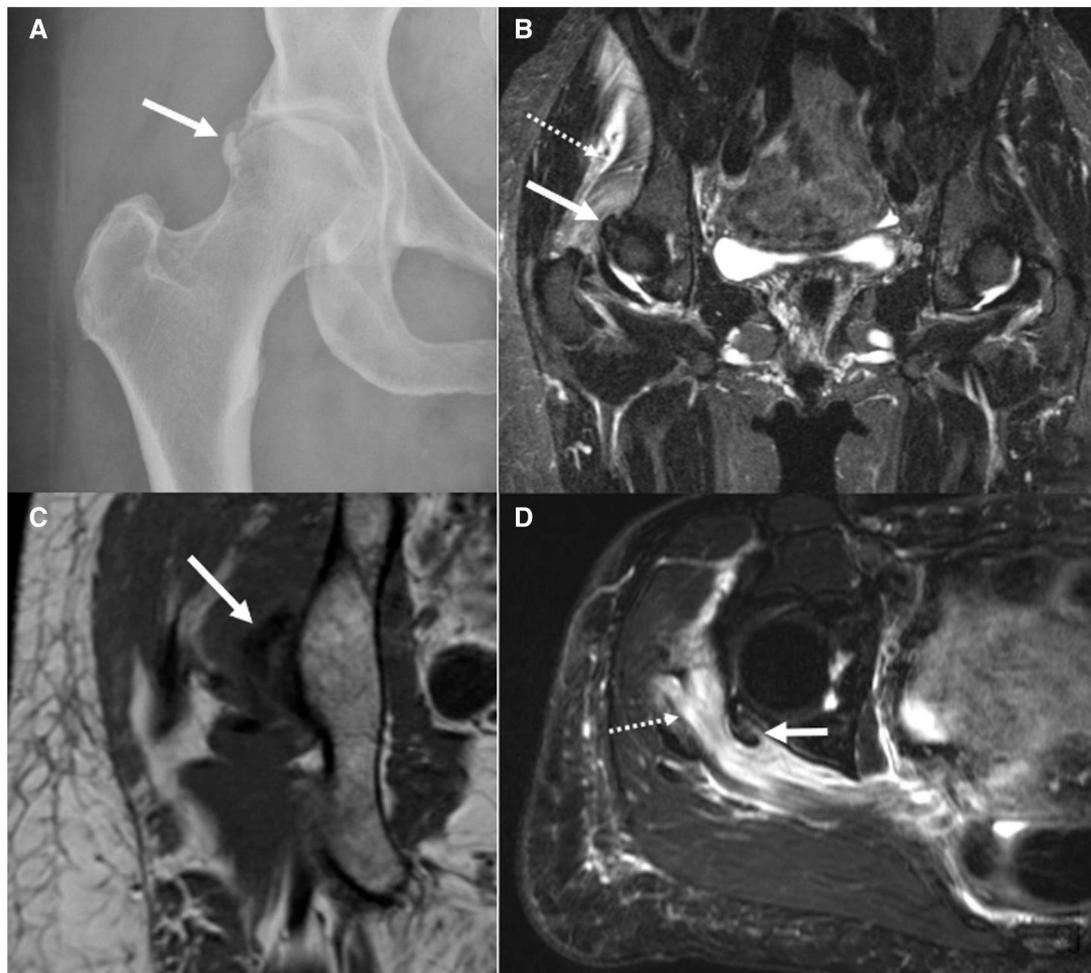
Conventional frontal radiograph of the right hip (A), coronal STIR and coronal T1W MRI (B and C), and axial fat-suppressed proton density MRI images (D) showing a curvilinear focus of calcification (white arrow) along the path of the rectus femoris tendon appearing as hyperdense structure on radiograph and as signal void on MRI. Extensive oedema and calcium debris (dashed arrow) of the adjacent gluteus minimus is seen in keeping with associated chemical myositis.
